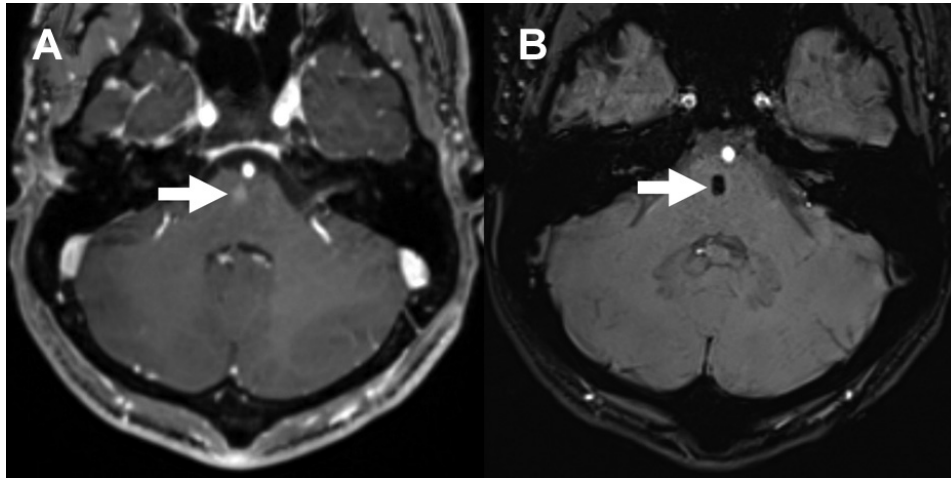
Example of a capillary telangiectasia MRI of an asymptomatic patient. In contrast-enhanced T1-weighted imaging (A) shows an area of brush-like hyperintensities in the right-sided pons, corresponding to a capillary telangiectasia. In susceptibility-weighted imaging (B) capillary telangiectasias are typically hypointense. In T2-weighted imaging (not shown), they are often invisible. MRI: magnetic resonance imaging
